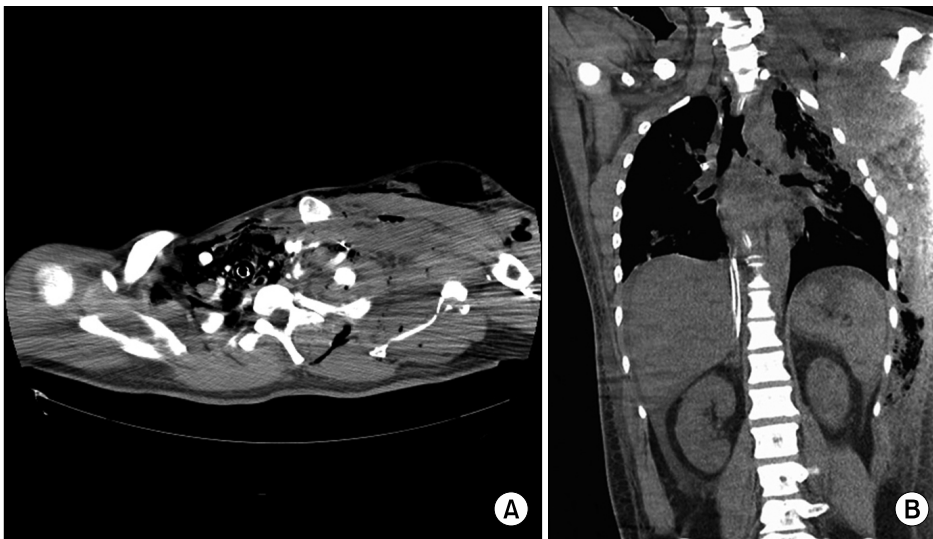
(A) A CT scan showed extravasation from the left subclavian artery and imprecise findings of the left subclavian artery and vein. (B) A chest CT scan showed complete transection of the left main bronchus. CT, computed tomography.
